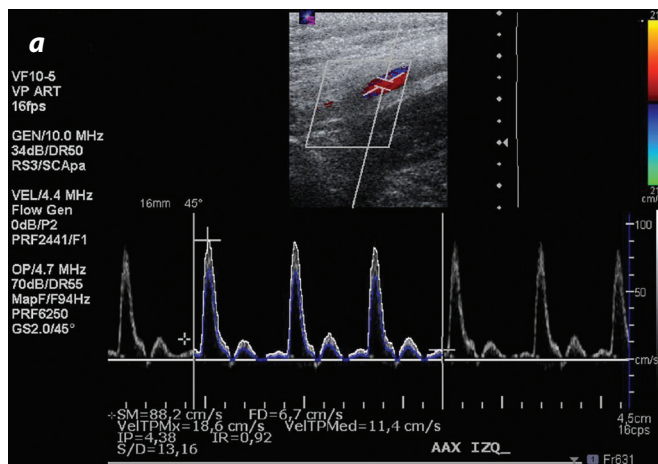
Triple mode Doppler ultrasound images, showing the axillary artery in a male patient (a) and in a female (b).
